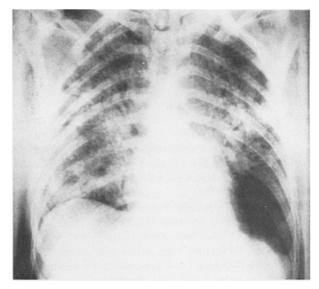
Case 2. Chest x-ray appearance of the same patient on the third day following pulmonary aspiration. At this time the patient was being ventilated with a pulmonary inspiratory oxygen percente of 80 and PEEP of 4 cms  $H_2O$ . The PaO2 in spite of these measures was only 5.07kPa
